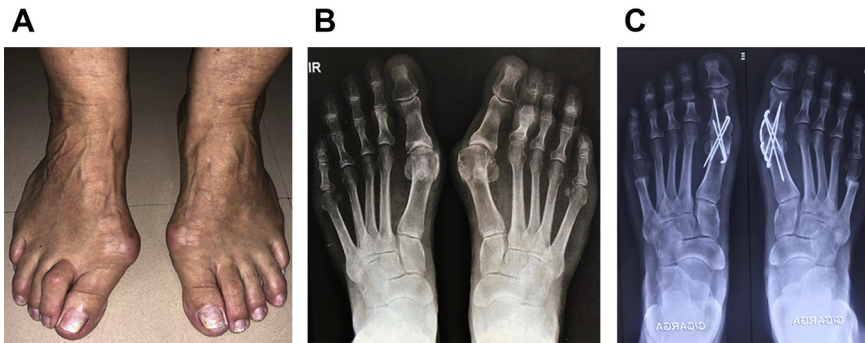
(A) Clinical aspect of severe hallux valgus deformity. (B) Radiographic examination of the deformity. (C) Correction of severe hallux valgus deformity through MTPJ arthrodesis fixed through crossed Kirschner wires with and without cerclage. Note the intermetatarsal angle correction.
